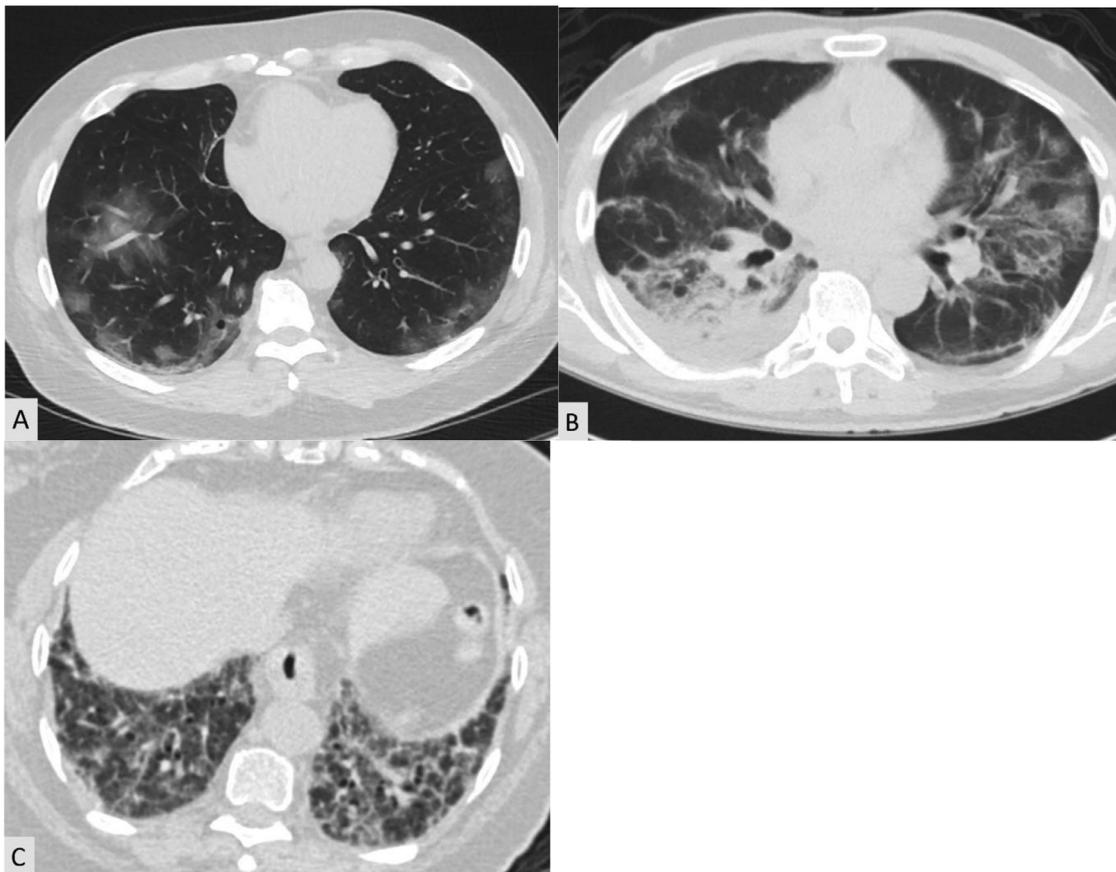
(A) Axial CT demonstrates mild severity of peripheral-predominant ground-glass opacities, some with a rounded morphology. Within the posterior right lower lobe, there is evidence of early organization, with subtle mild peripheral linear opacities paralleling the pleura with 1-2 mm of subpleural sparing; (B) Axial CT demonstrates moderate peripheral-predominant ground-glass and consolidative opacification with a greater degree of organization, as evidenced by progressive peribulbar reticulation and linear opacities paralleling the pleural surface. There is also a small right pleural effusion, a less frequent finding in COVID-19 as compared with other pulmonary infections; (C) Axial CT demonstrates severe peribulbar reticulation with mild architectural distortion and traction bronchiectasis.
